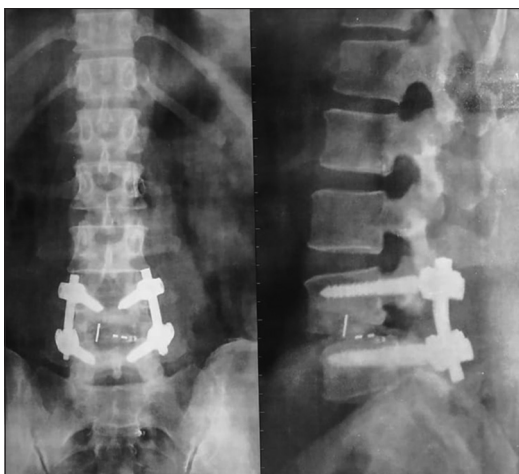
X-ray of lumbosacral spine showing pedicle screw and interbody fusion at L4–L5 level
